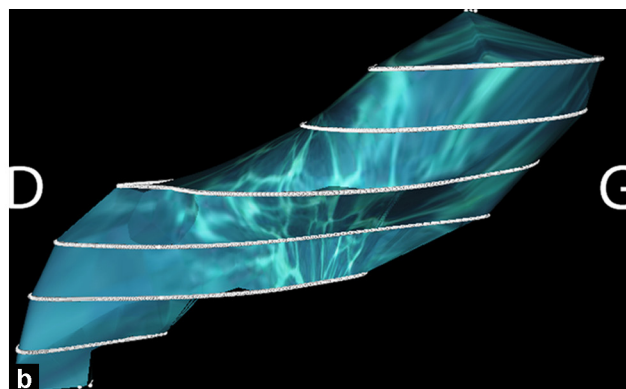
Manual segmentation of the right piriformis muscle on an axial T1-weighted cross-section (a) then 3D volume rendered view of the segmented piriformis muscle (anterior view) (b).
